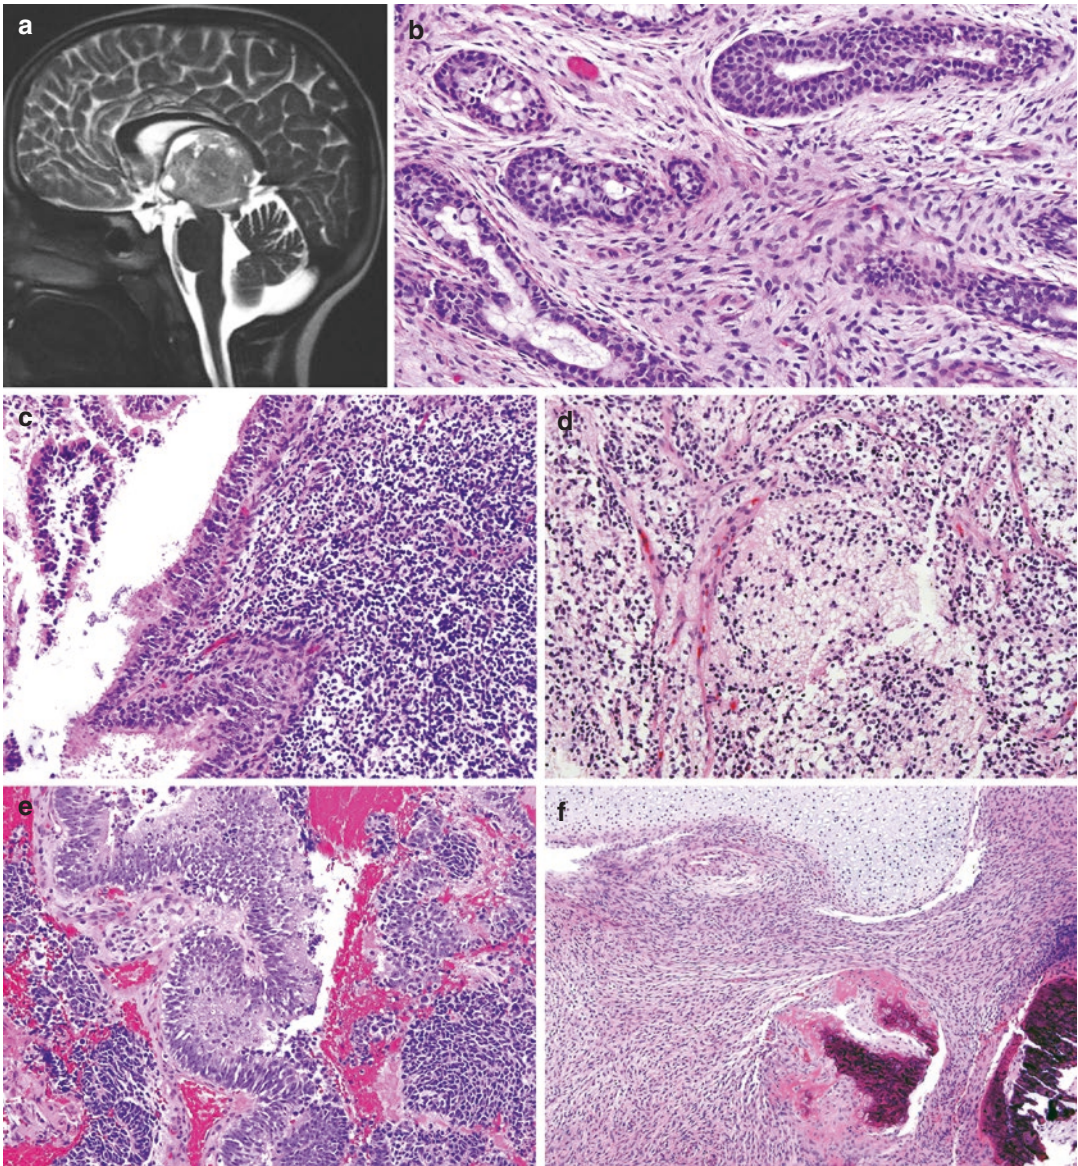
Immature teratoma of the pineal gland. This immature teratoma presented as a large pineal region mass (T2-weighted MRI) (a). This tumor contained glandular epithelium in a cellular stroma (b), neuroepithelium (c)
